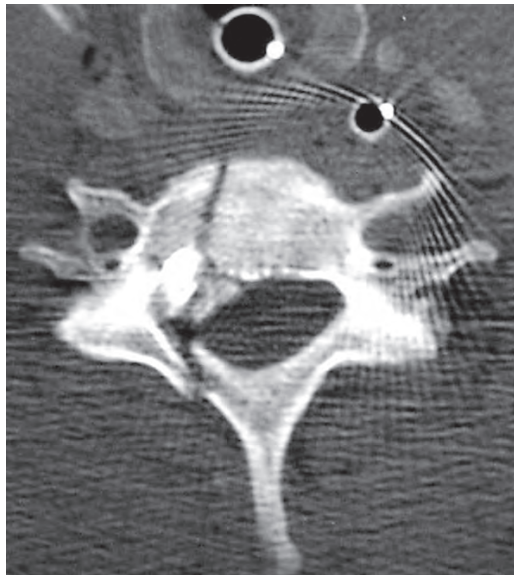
CT showing three column injury with bullet lodged in the spine
